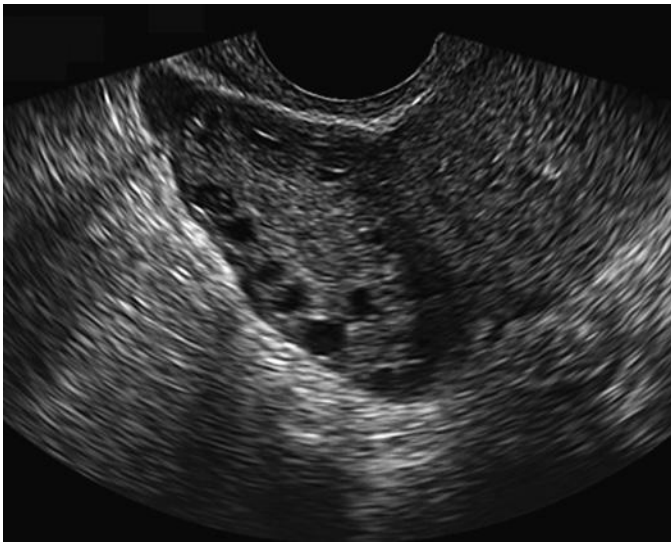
Polycystic ovary syndrome (PCOS). Gray-scale transvaginal sonographic image demonstrating an enlarged right ovary with over 12 small (2- to 9-mm) follicles, located peripherally. The central portion of the ovary has a more solid, echogenic appearance. Similar ovarian morphologic pattern was noted on the left (not shown).
